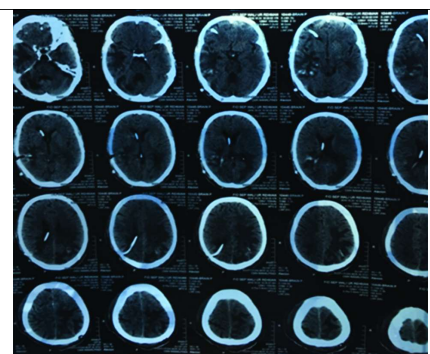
CT scan images showing ill-defined hypodense areas and small focal hyperdensities in left parietal lobe, right temporal lobe and cerebellar hemisphere, suggestive of post-surgical changes. No definite mass lesion is seen in these images.
